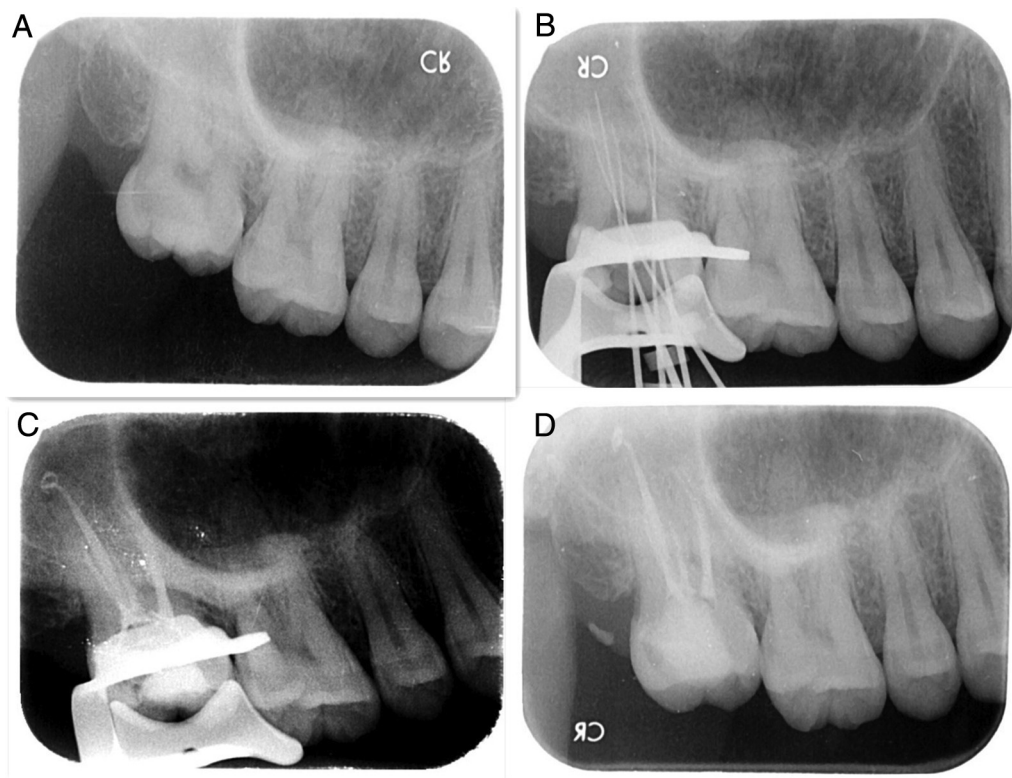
(A) Preoperative radiograph of tooth #2. (B) Working length determination. Radiograph with K-files showing 5 separate root canals. (C) After root canal treatment. (D) One-month follow-up. No obvious abnormalities were observed. Restoration was suggested to the patient.
